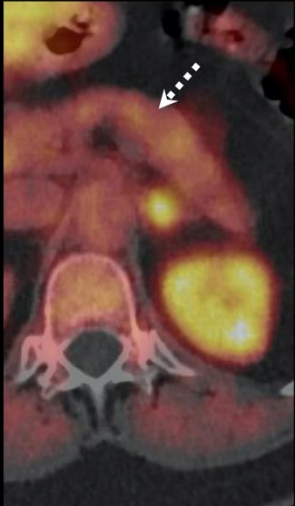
Discordant results of carbidopa-assisted ^{18}F -DOPA and ^{68}Ga -DOTATOC PET/CT in two patients with pathologically proved insulinoma (arrows). (A) Early ^{18}F -DOPA+/Delayed ^{18}F -DOPA -/ ^{68}Ga -DOTATOC+. (B) Early ^{18}F -DOPA-/Delayed ^{18}F -DOPA-/ ^{68}Ga -DOTATOC+.
